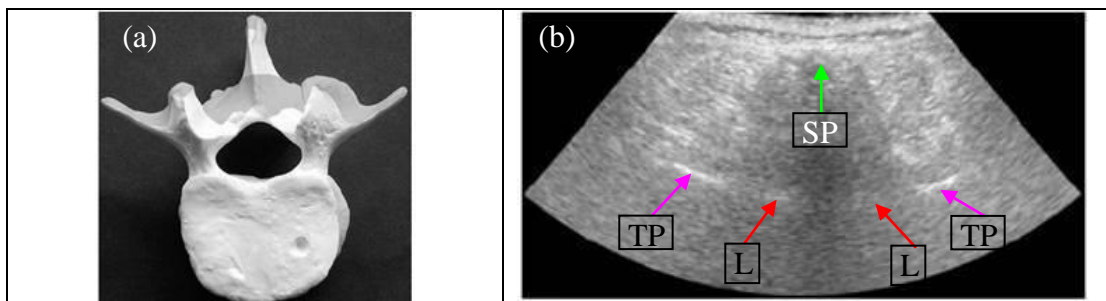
13. Region of the Lumbar Vertebra Shown in Ultrasound Images
